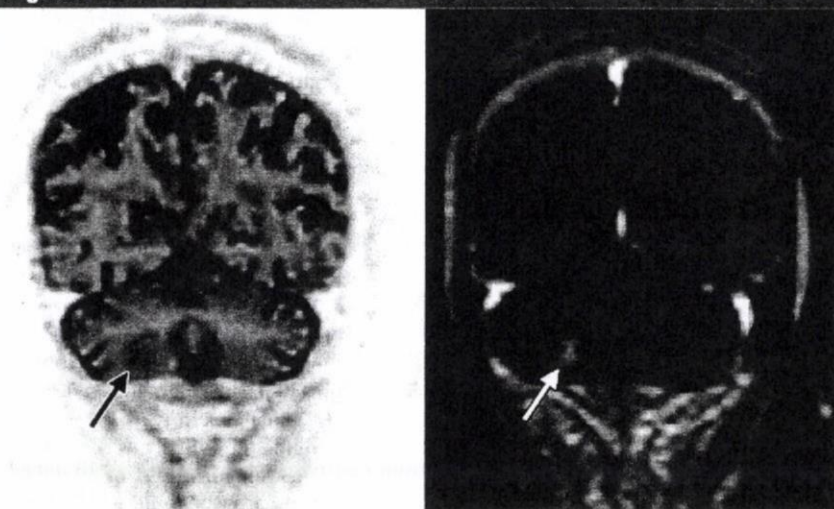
Images in 77-year-old man with adenocarcinoma and brain metastasis. Left: Whole-body DW image (5759/70/180) in coronal plane equivocally demonstrates brain metastasis, which was scored as 3, with slight high signal intensity (arrow). Right: Contrast-enhanced T1-weighted in-phase MR image (100/4.6; flip angle, 75°) in coronal plane shows brain metastasis (arrow), which was scored as 5. This was diagnosed as a false-negative case at whole-body DW imaging and as a true-positive case at whole-body MR imaging with and that without DW imaging.
